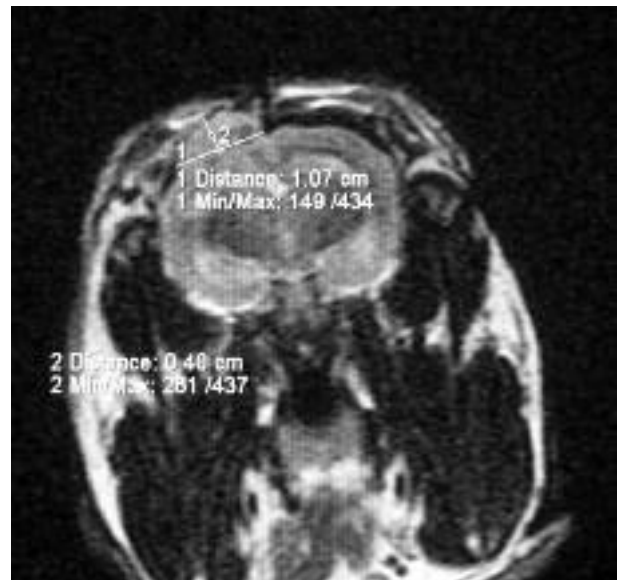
Measuring protrusion of brain tissue from the craniotomy site on the MR image on the perpendicular line extending from the tangential line drawn across the craniotomy site.
